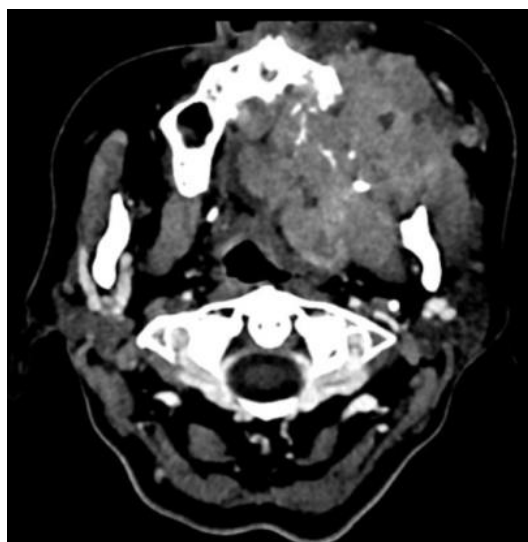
(P1) – CT scan with contrast, cervical region, coronal section – maxillary sinus extension of the oral mass
